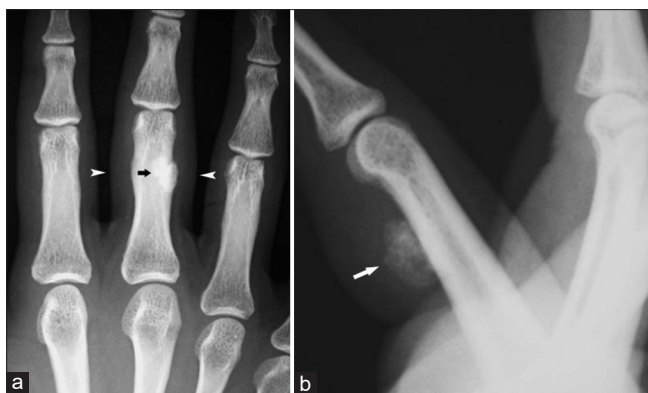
(a) Posteroanterior radiograph of the right second to fifth digits shows a diffusely sclerotic lesion projecting over the proximal phalanx of the middle finger (arrow). Note soft-tissue swelling in the affected finger (arrowheads). (b) The lateral radiograph reveals an ossified lesion (arrow) projecting on the volar aspect of the finger
